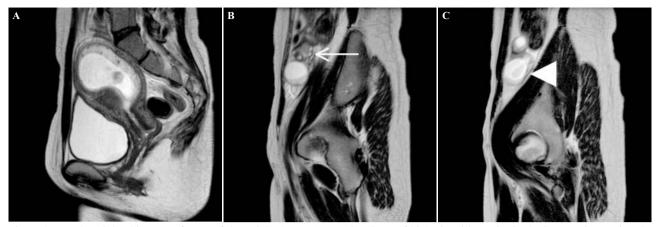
T2-weighted images of MRI of the pelvis show (a) gestational sac of high-signal intensity in the intrauterine cavity, (b) the right ovary (arrow), and (c) a cystic lesion of high-signal intensity located between the uterus and the right ovary, indicating tubal pregnancy (arrowhead).
